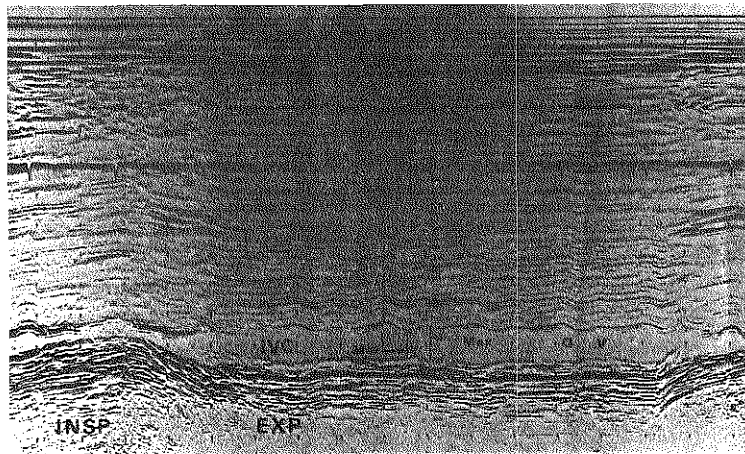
Normal M-mode inferior vena cava (IVC) echocardiogram showing how measurements were made. IVC dimensions were measured at the onset of the QRS, minimal systolic dimension before onset of the "v" pulsation (Min) and maximal dimension during the "v" pulsation (Max). INSP = inspiration; EXP = expiration; a = "a" pulsation; v = "v" pulsation.
